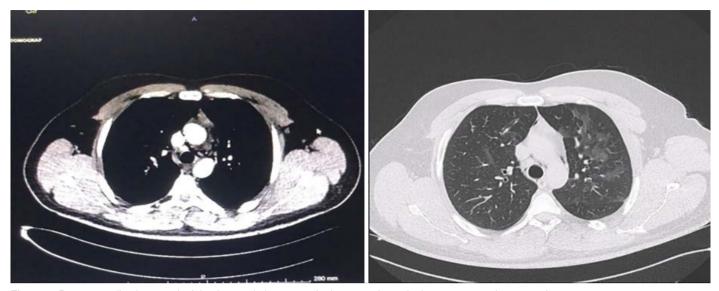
Pneumomediastinum and minimal ground glass areas in the parenchyma in thorax computed tomography.
